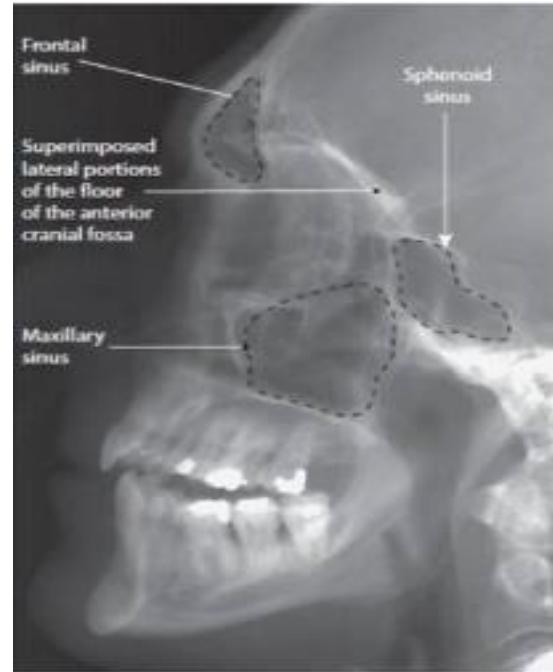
Labelled radiograph showing important
